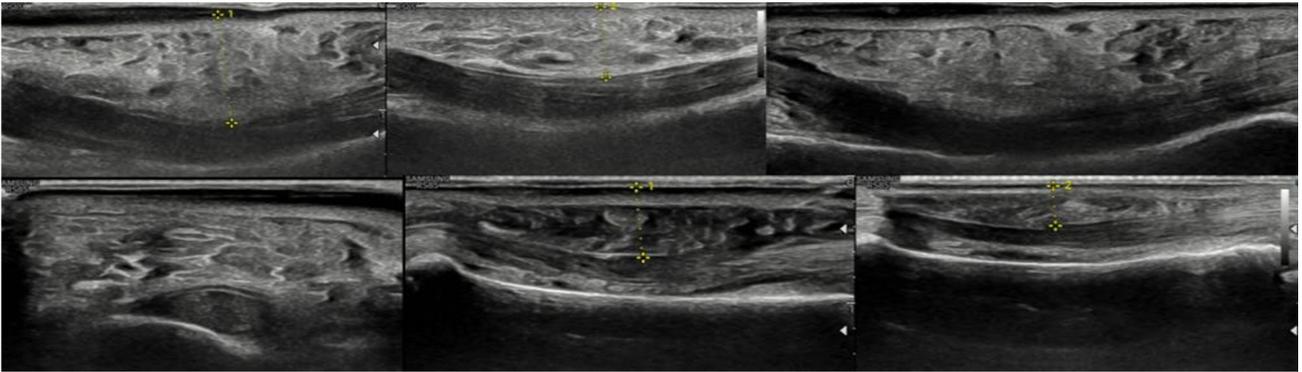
Edematous thickening of the subcutaneous soft tissues on ultrasound examination.
